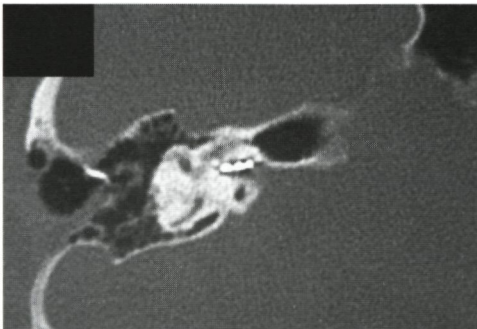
Postoperative CT scan right petrosal bone (coronal view): the electrode array penetrates the internal auditory canal.
